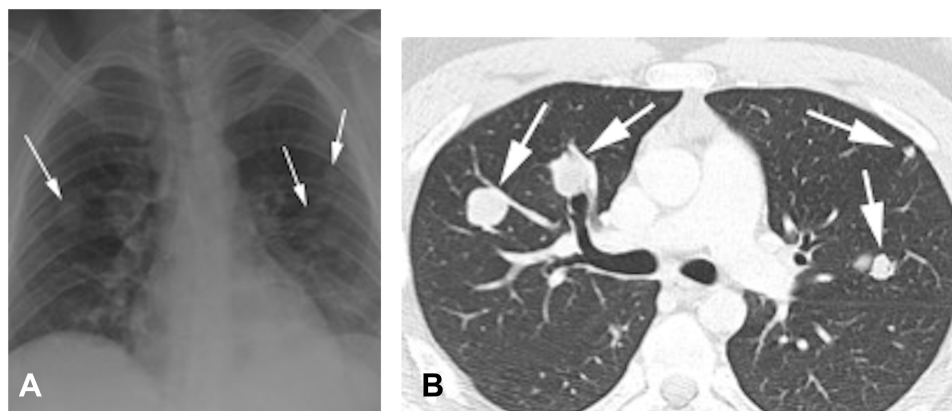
Pulmonary metastases. Same patient as [Figure 8](#). (A) Chest radiograph showing multiple pulmonary masses and nodules predominantly in bilateral mid-zones. (B) Chest CT lung window settings showing multiple lung nodules in right-middle and left-upper lobes.
